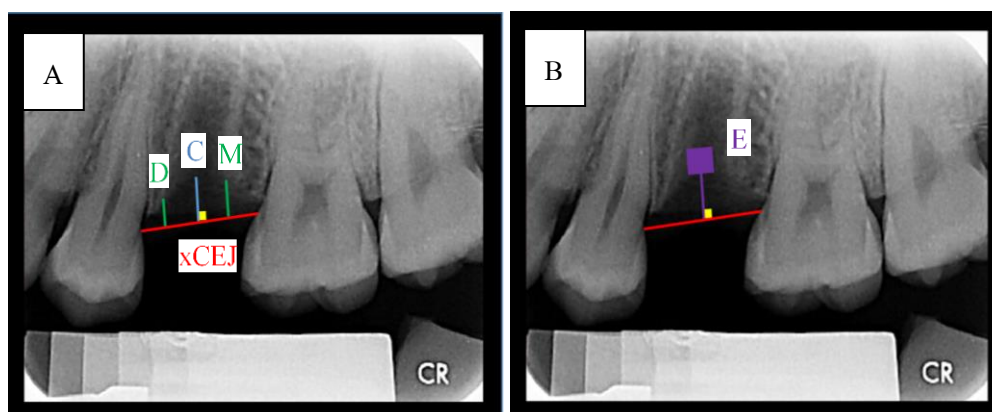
The resorption of marginal bones and the width of the socket orifice at the extraction site. xCEJ-line; radiographic cemento-enamel junction line, C; bone resorption distance at the center of the socket orifice, D; bone resorption distance at the distal side, M; bone resorption distance at the mesial side, E; density measurement area
